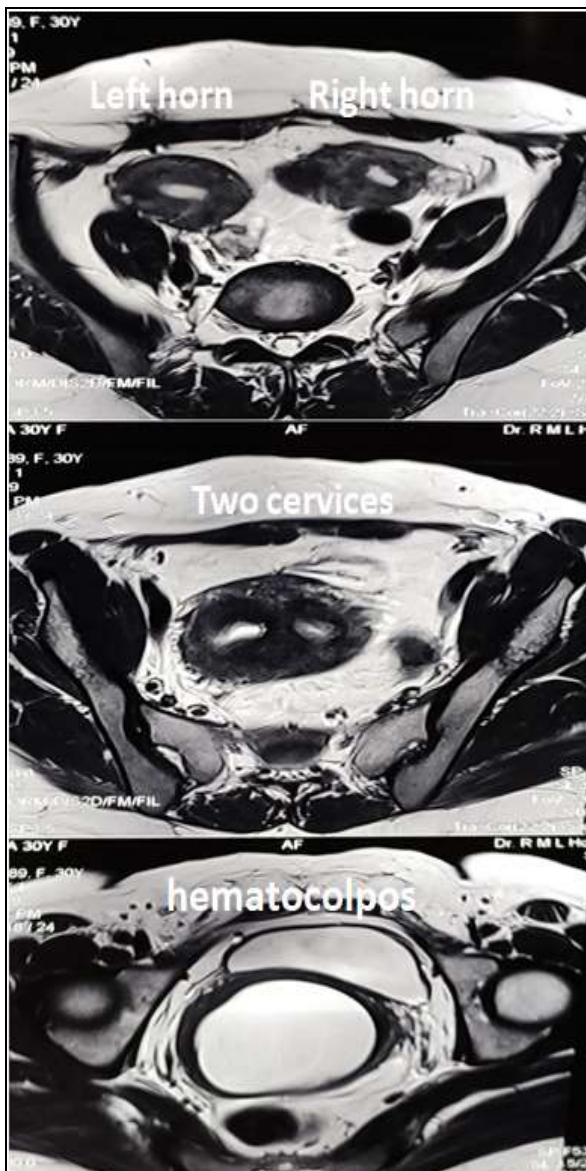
MRI showing two separate uterine horns (upper), two cervixes (middle), hematocolpos (lower)
